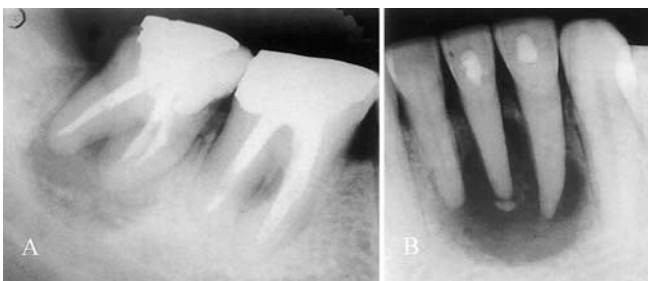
Periapical radiographs showing well-defined radiolucency associated with the apex of the right mandibular second molar (A) and mandibular incisors (B)
